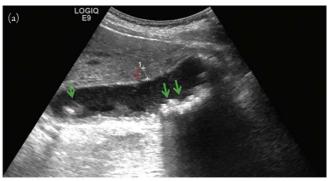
Gallbladder empyema on ultrasound and computed tomography (CT). Panel (a) shows a gallbladder ultrasound with typical signs of infection, including severely irregular wall thickening, stones, sludge, and air. The CT plane in Panel (b) shows a severely dilated gallbladder with surrounding pericholecystic fluid (blue arrow) and gas in the lumen of the gallbladder (orange arrow). Adapted from Figures 1 and 2 of Mehta V, Yarmish G, Greenstein J, Hahn B. Gallbladder empyema. *J Emerg Med.* 2016;50(6):893–894.
